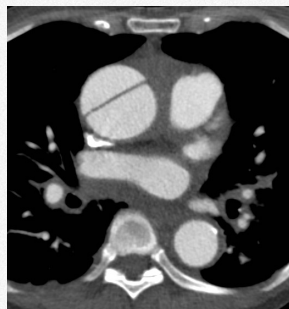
CTA image demonstrating a Type A dissection
